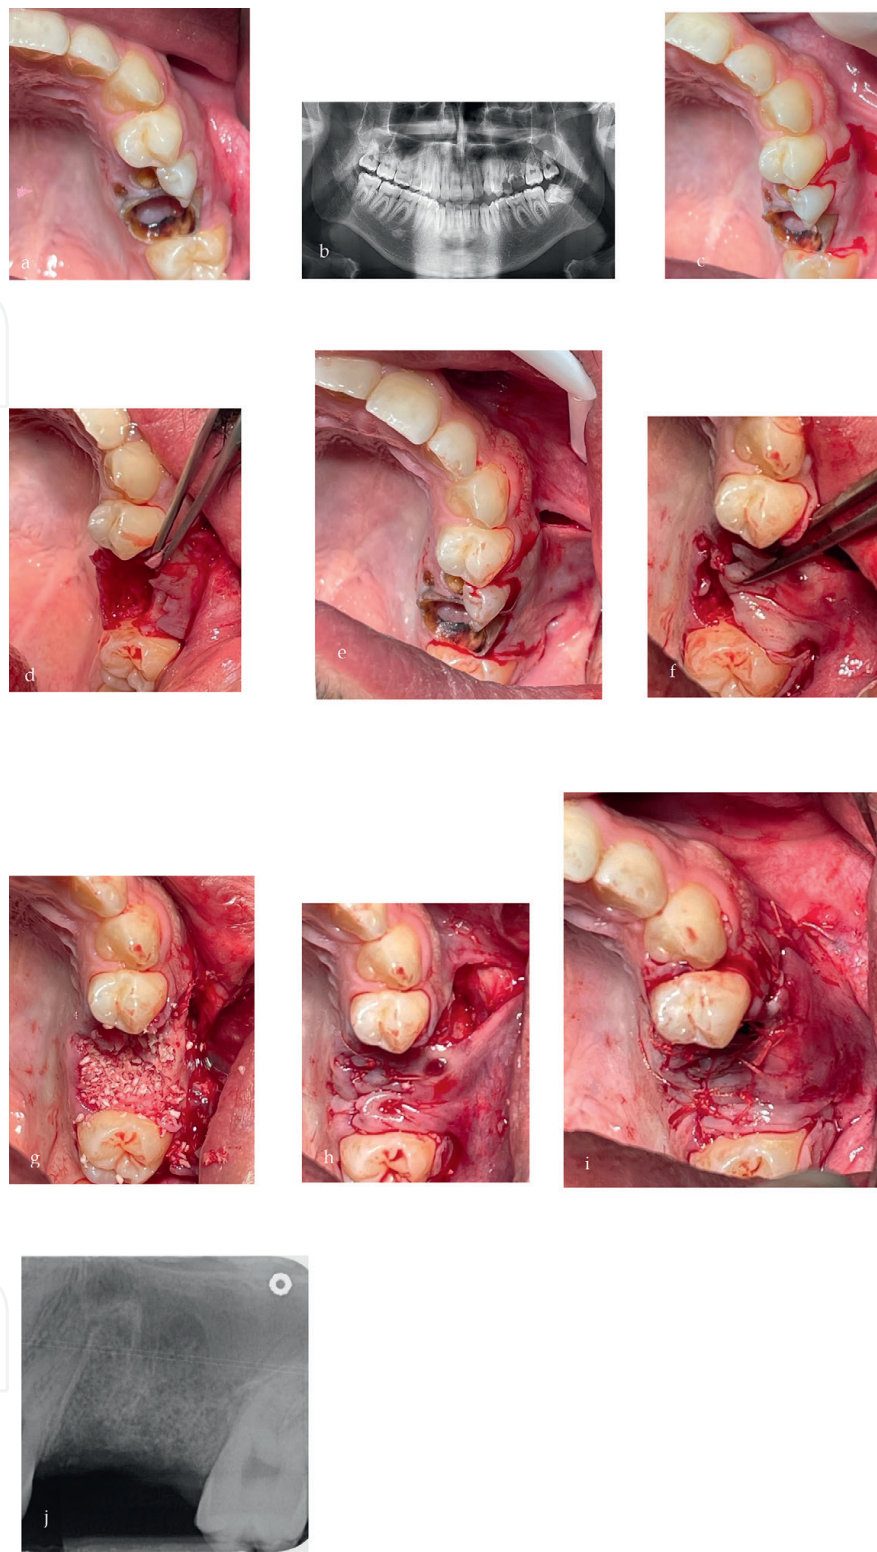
Back-cut technique, case 1. (a and b) Clinical and radiographic views, crown destruction with periapical lesions involved the left maxillary second premolar, and the first molar. (c) A trapezoid flap was designed and obtained by intrasulcular and two releasing incision. (d) Intraoperative view demonstrates the disability of the flap to cover. (e) Intraoperative view shows that the flap rotation and advancement coronally obtained by the back cuts will enhance the sockets seal. (f) Particulate bone substitute is used to fill the socket. (g) The sockets' preservation with particulate bone graft. (h) The sutures at the occlusal part of the sockets obtained by flap rotation and advancement demonstrate the primary closure. (i) Primary closure at the bone-augmented socket without affecting the vestibular depth; a wide base flap was achieved. (j) Periapical view of the treated site at four months after the surgery demonstrates the bone graft.
